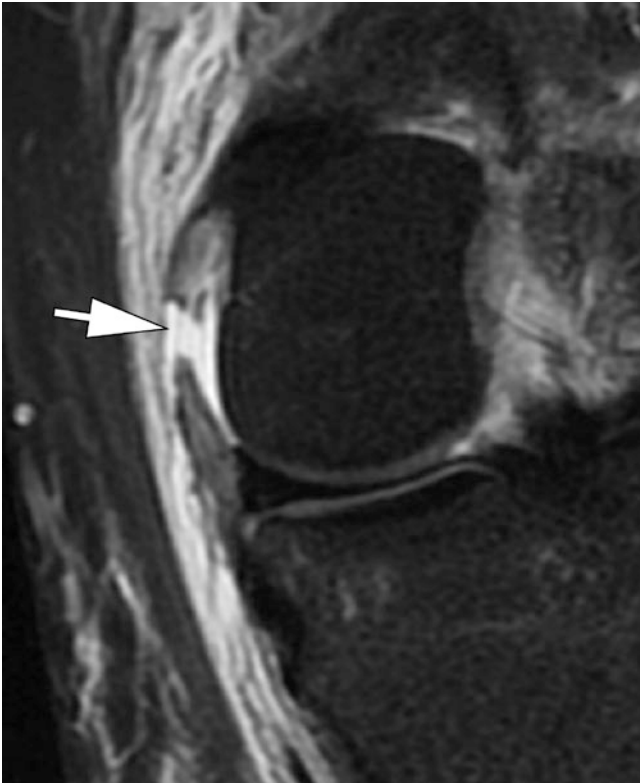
Posterior oblique ligament tear. Coronal T2-weighted image with fat suppression. Complete tear of the POL (arrow) with exuberant surrounding edema
